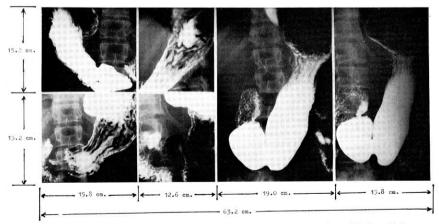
Example of roentgenograms of a stomach and duodenum recorded by a full size roll film.
